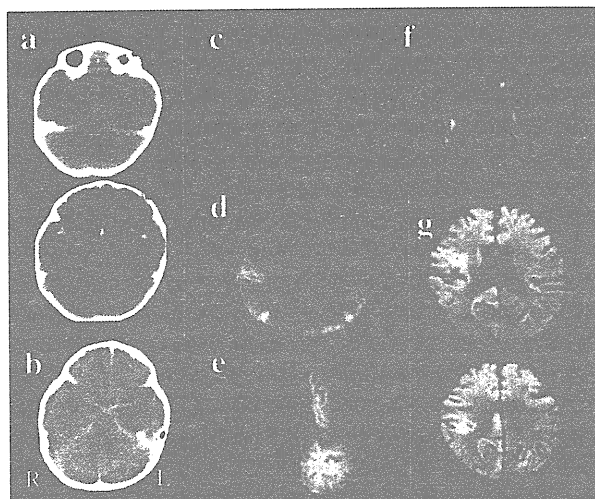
(a) Brain CTs on 2nd and 21st day of hospitalization in Case 1 showing disappearance of cistern between brainstem and cerebellum (upper image) and severe brain edema (lower image). (b) Brain CT on admission showing severe brain edema in Case 2. (c–g) Brain MRIs showing abnormal high intensities in diffusion-weighted images in Cases 6, 7, 12, 11 and 10, respectively.
